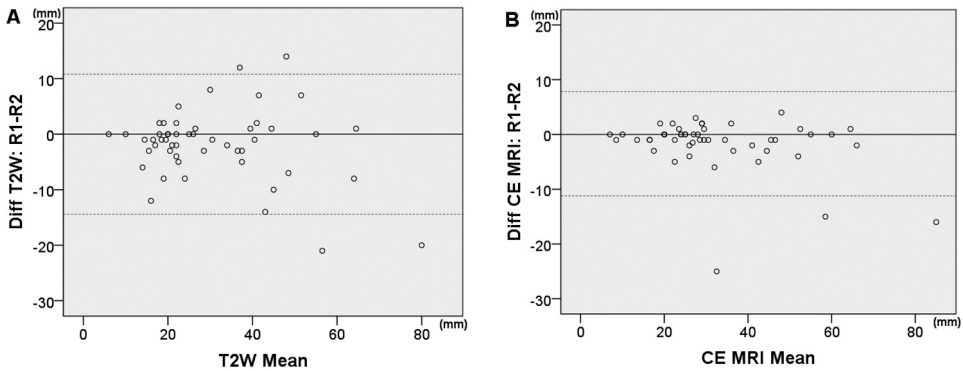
Agreement of vital tumor measurement by 2 readers for T2W (A) and CE MRI (B) on 51 lesions. Diff, difference.
